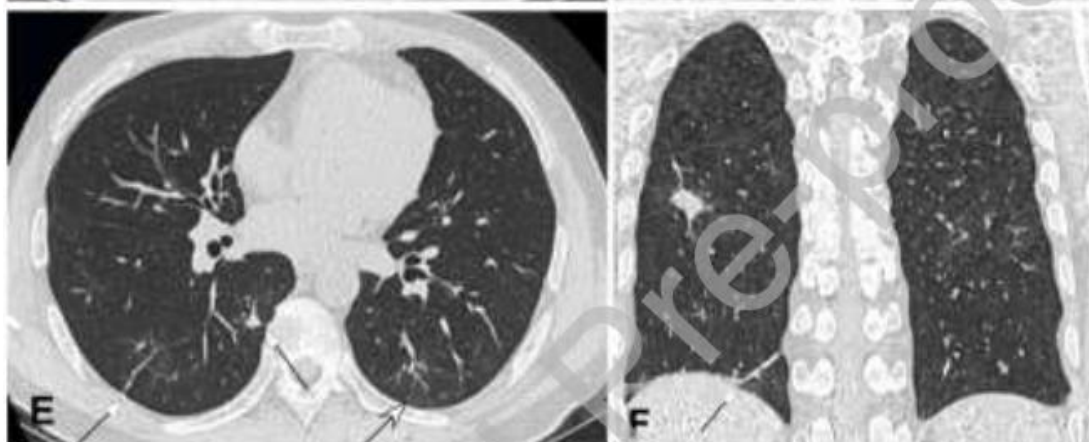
Severe novel coronavirus pneumonia in a 34-year-old man with fever and cough for ten days before admission. A&B. Computed tomography axial (A) and coronal (B) plane revealed multiple lesions of ground glass opacity, consolidation and fibrosis with symmetrical distribution in bilateral lungs, with the lesion extending towards the pulmonary hilum. Air bronchogram was observed within the lesion. C&D. Four days after treatment, the extent of lesion shrank with decreased density and formation of fibrosis.
